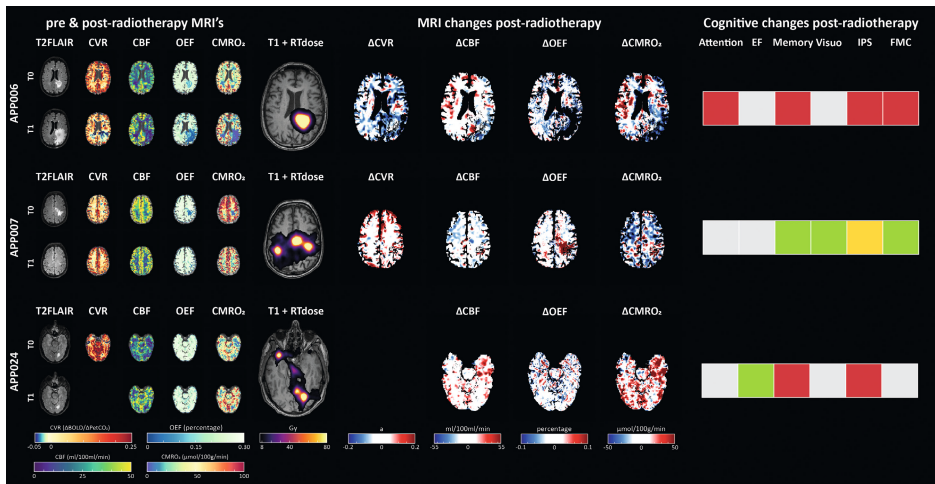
Visual comparison of MRI-related and cognitive changes in three subjects with different radiotherapy responses. Subject 006 had new brain metastases, subject 007 brain metastases shrinkage and subject 024 had a mixed response whereby some brain metastases grew and some shrunk. Pre- and post-radiotherapy MRI maps are shown separately for pre-radiotherapy (T0) and three months post-radiotherapy (T1). Additionally, the delivered radiotherapy dose and difference scores (T1-T0) for the MRI maps are shown alongside the cognitive changes that were observed across the cognitive domains. Hereby grey indicates stable performance, green improvement, red decline and yellow mixed response. As patient 24 did not perform the CVR assessment post-radiotherapy, no difference maps for CVR are available.
